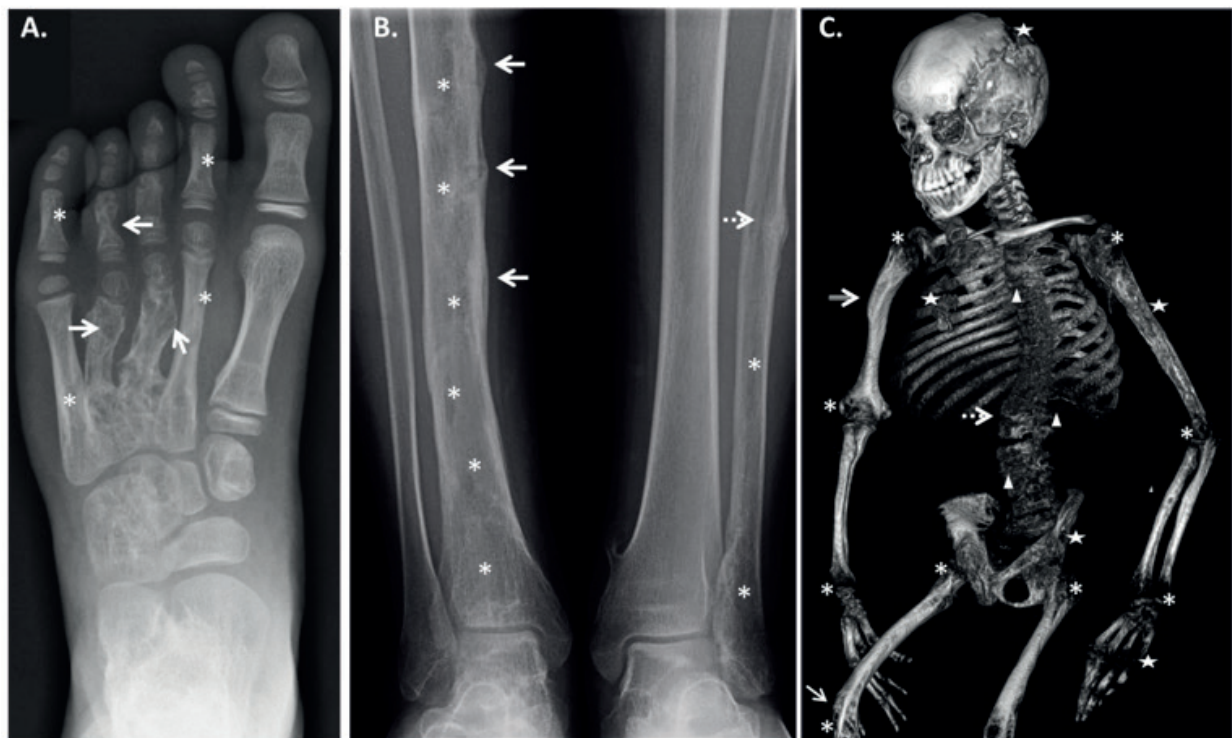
Representative X-ray imaging of the CSHS cohort. (A) CSHS101 left foot radiograph showing dysplastic lesions in phalanges and metacarpals of digits 2-5. In contrast, the bones of the first digit are spared from dysplasia consistent with the syndrome's mosaic nature. Dysplastic bone lesions are characterized by areas of mixed lytic/sclerotic areas. In this radiograph the lytic component is more prominent in digits 3 and 4 (arrows), while the sclerotic component is more noticeable in digits 2 and 5 (asterisks). (B) Radiograph of mid and lower shafts of tibiae and fibulae in subject CSHS105. The right tibia shows cortical stress pseudofractures with periosteal reaction along the mid shaft (arrows) in addition to irregular lucent changes indicative of dysplasia (asterisks). A healing stress fracture is also observed in the mid left fibula (spotted arrow) with lucent changes in its mid and distal shaft (asterisks). The left tibia appears normal and unaffected suggesting that dysplastic bones are more prone to fracture under the same systemic abnormalities than non-dysplastic bones. (C) Skeletal 3-D CT reconstruction of CSHS106 skeleton showing severe rickets (asterisks) and lower limb bowing (arrow) secondary to osteomalacia. Patchy areas with lytic lesions are seen throughout the skeleton (stars) in addition to areas of sclerosis (compound arrow). This was the only patient in the cohort in which vertebral dysplasia was identified (triangles). Scoliosis, a frequent manifestation in CSHS, was severe in this patient (spotted arrow).
